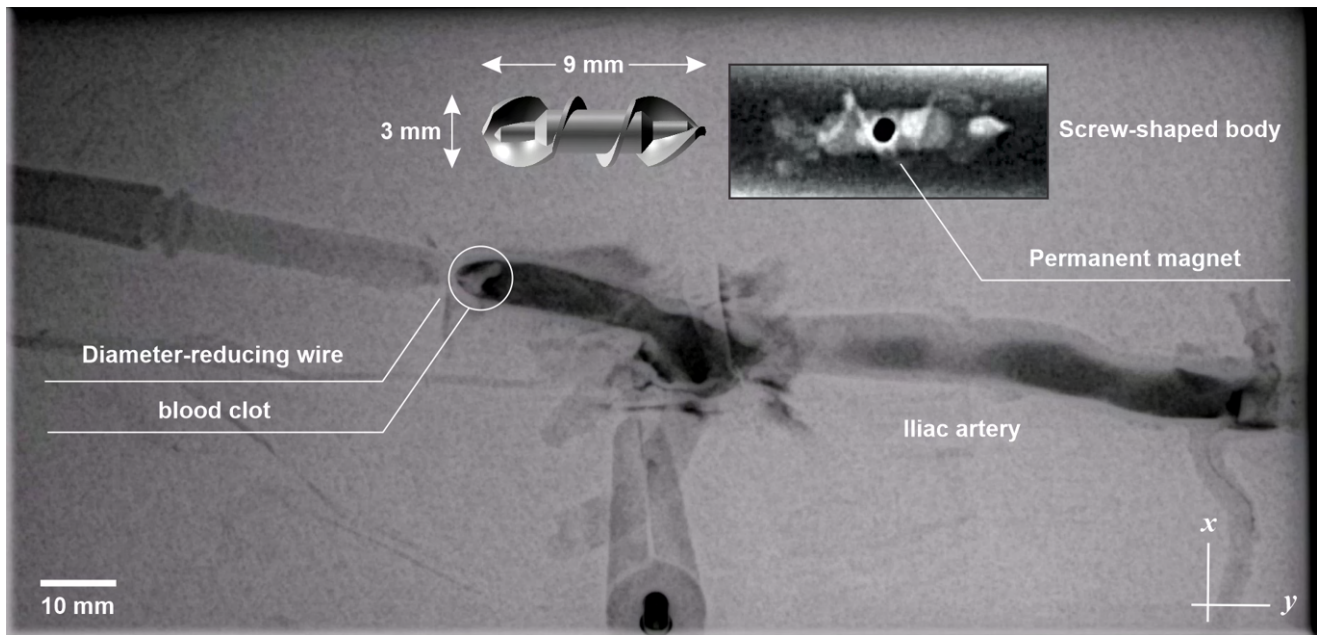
The *ex vivo* endovascular thrombosis model is depicted through X-ray Fluoroscopy imaging while injecting a radiocontrast agent along the negative *y*-axis. A diameter-reducing wire is used to trap the blood clot. The untethered magnetic robot (top-right inset) is inserted from the proximal end of the iliac artery and guided toward the blood clot.
